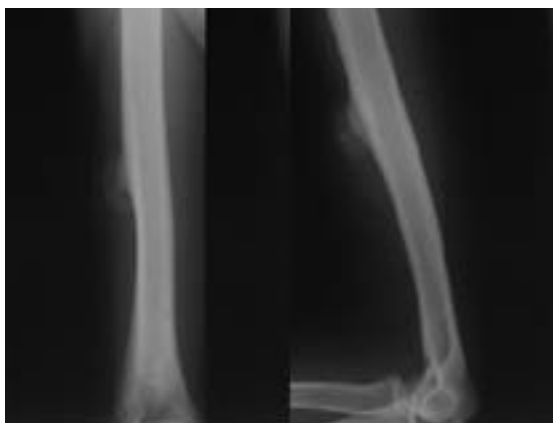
Anteroposterior and lateral radiographs of the right humerus showing broadly based osseous excrescence in the humeral shaft. Definable plane separated from underlying cortex is also seen.
